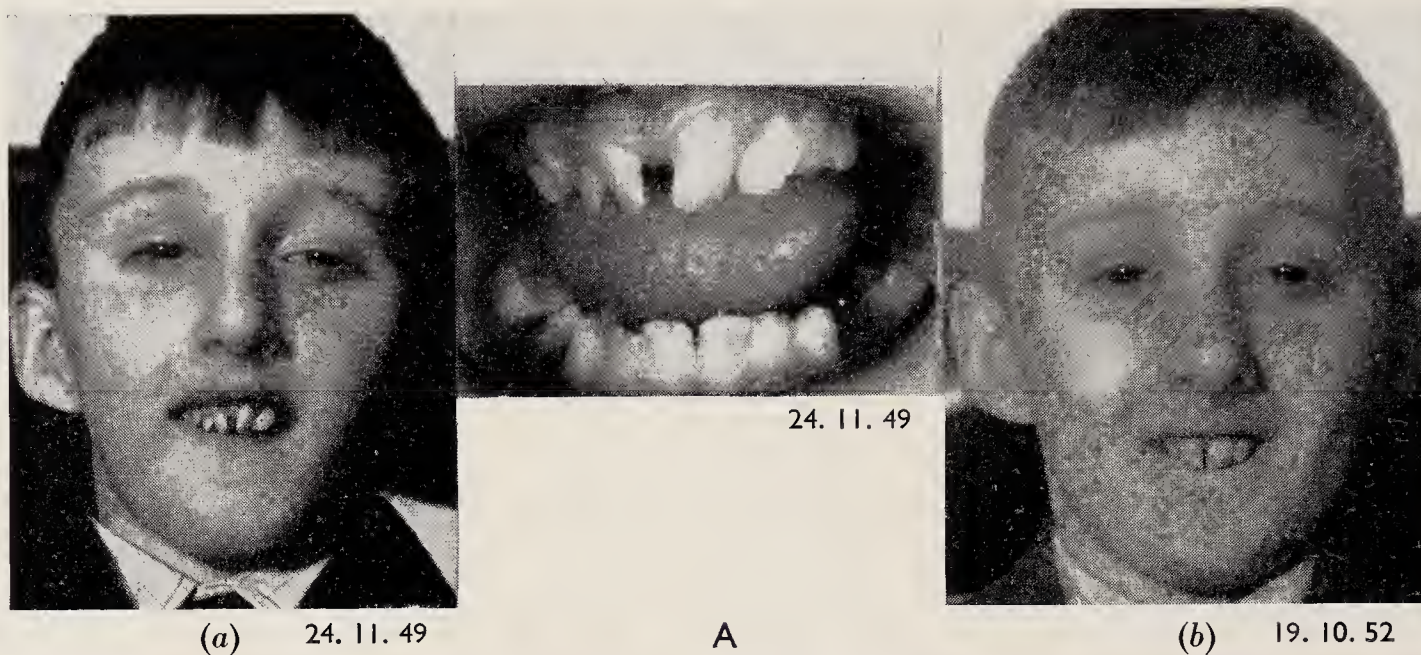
Case 5 (see Fig. 4). A, (a) Before torsion; (b) Two years after torsion. B, $\underline{1|1}$ after six years (supplemental $\underline{2|2}$ have been removed). C, Radiograph before torsion. D, After splinting. E, Six years later.
